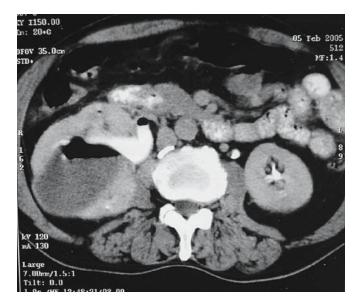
A CT scan shows an infected renal cyst with fair function of the right kidney
